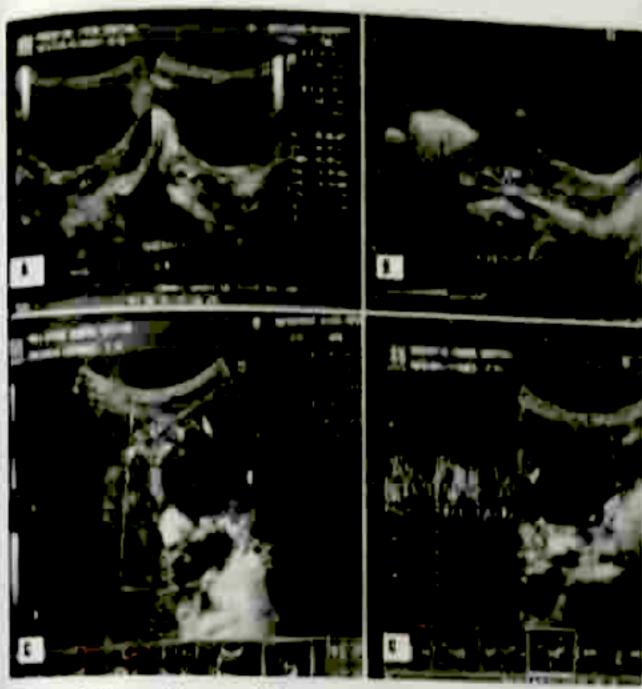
Transabdominal ultrasonographic scan showed (A)the left ovary converted to a heterogenous solid mass measuring 4.9cm x 4.4cm x 3.5cm, (B) The uterus is slightly enlarged for age (4.9cm x 2.5cm x 1.7cm) with thin endometrium (0.3cm) and intact subendometrial halo, (C) On color-flow mapping, the mass has both central and peripheral vascularities, (D) Doppler interrogation revealed low resistance indices (R1 0.43, P1 0.53) suggestive of malignancy.
